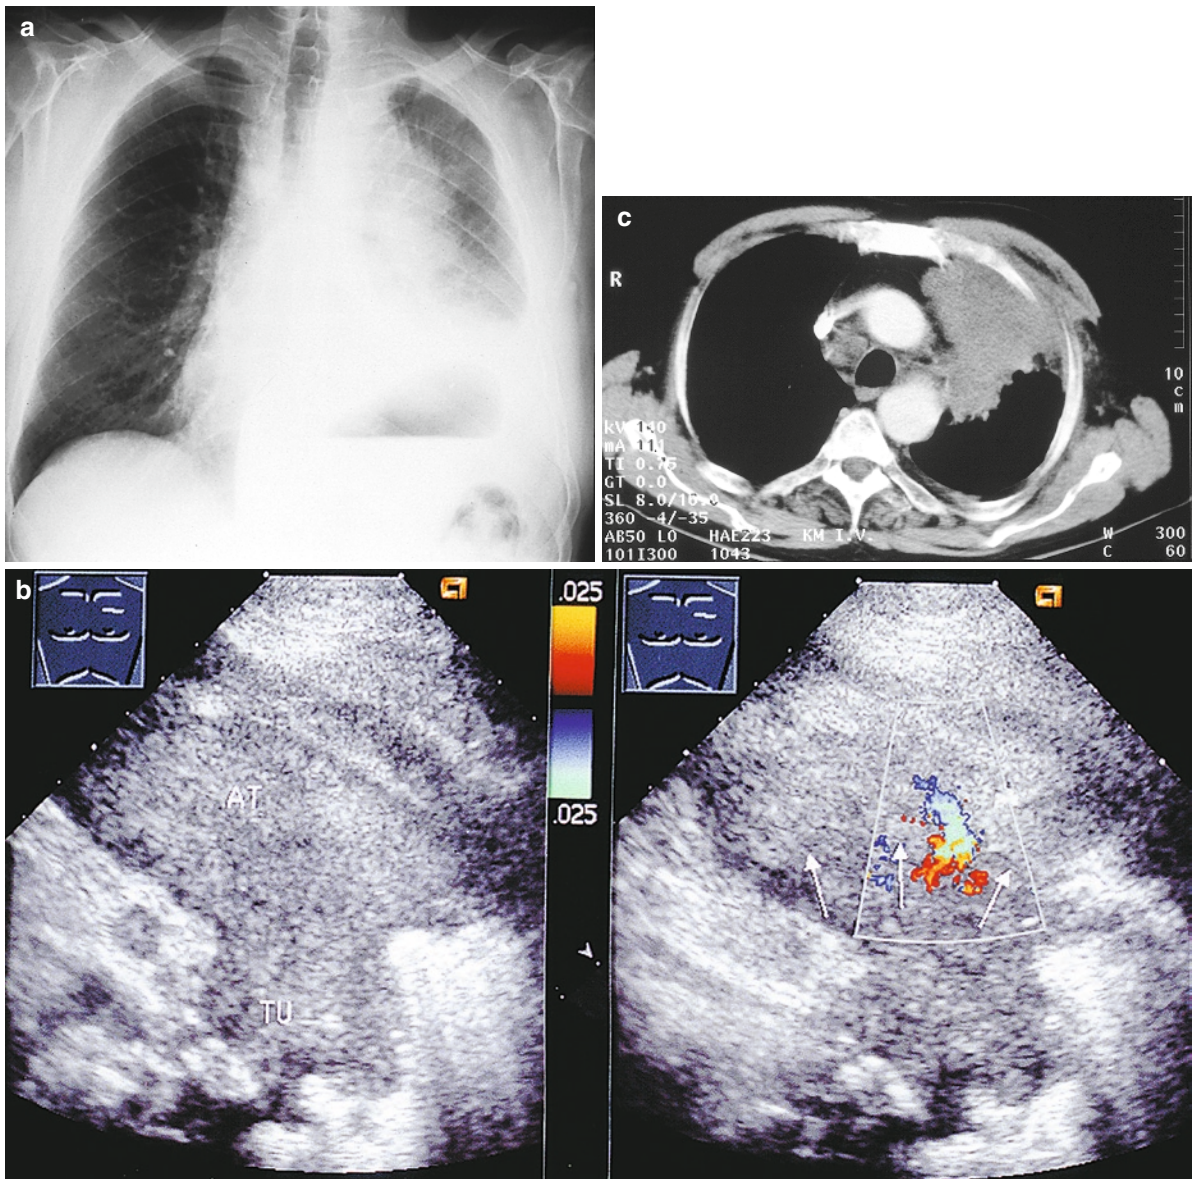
A 44-year-old man with a bronchial carcinoma. (a) Chest X-ray: signs of left-sided upper-lobe atelectasis and dysatelectasis in the lower lobe. (b) Sonography: left-ventral intercostal echo transmission shows atelectasis in the upper lobe. The
